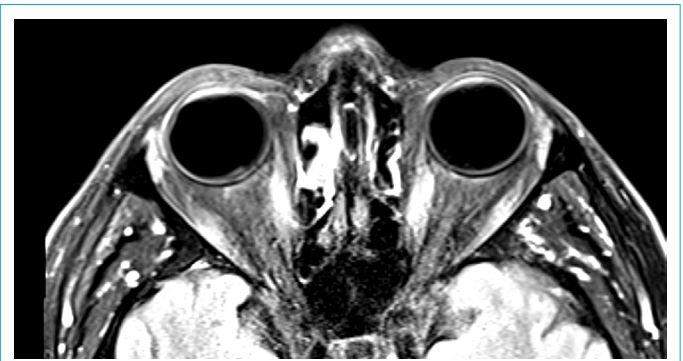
Orbital axial FLAIR images.
